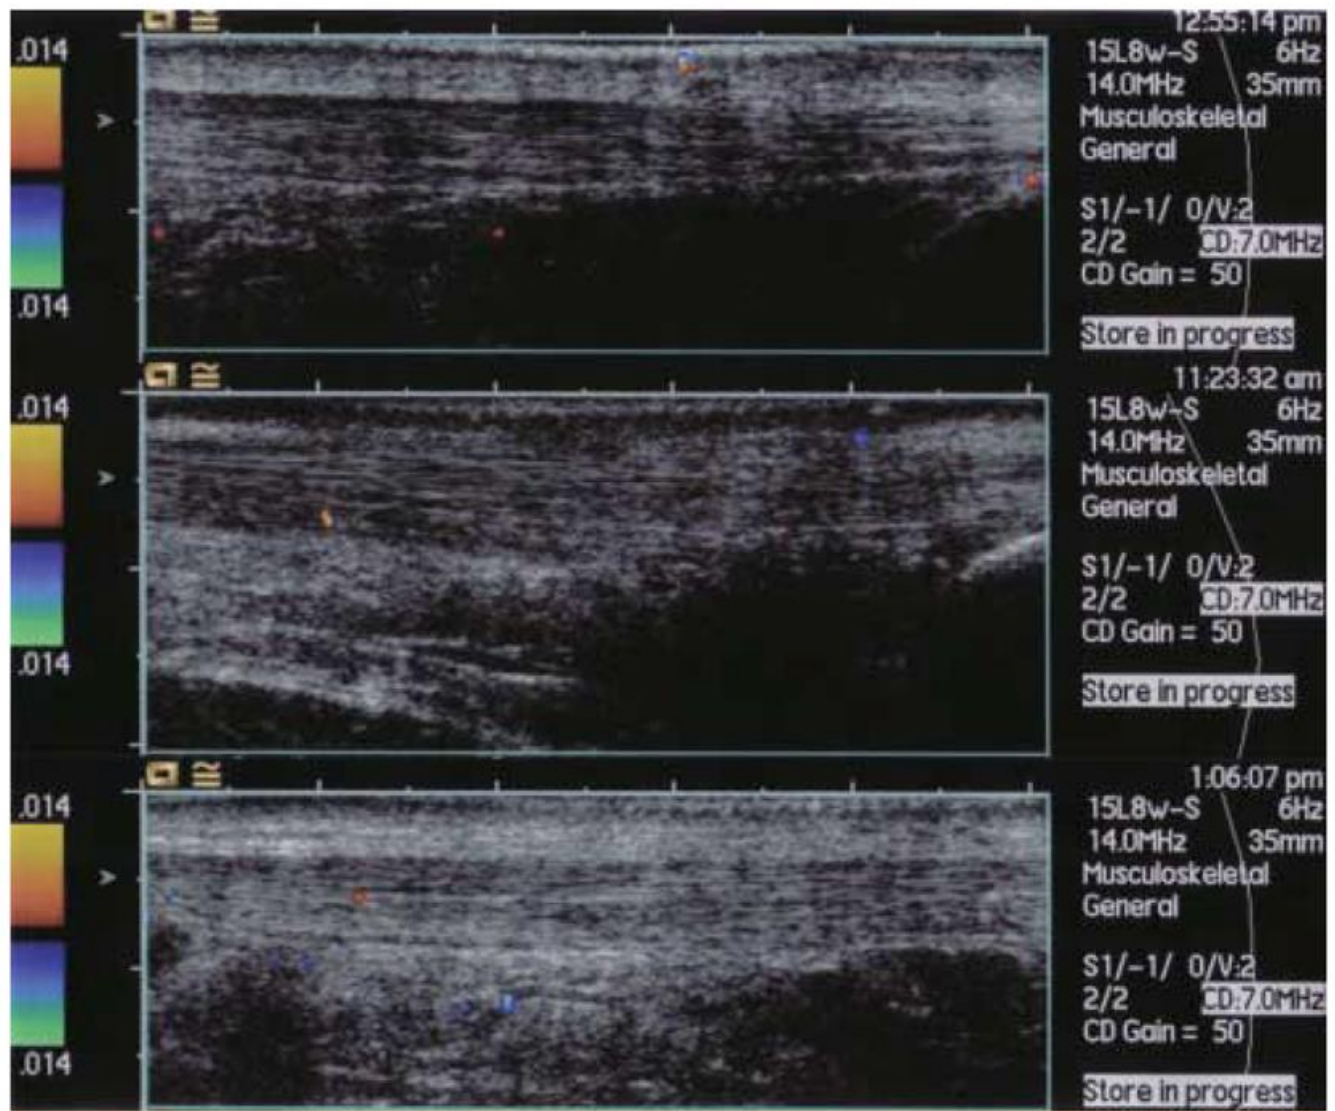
Longitudinal color Doppler images of normal and abnormal Achilles tendons. Cranial is oriented left and posterior is oriented above. In all images, the color Doppler box fills the image from side to side. Inside the box, the signals are analyzed for motion, which is equal to flow when the subject and examiner are immobile. Upward movement in the image is given red and orange hues – downward movement blue and green hues.
